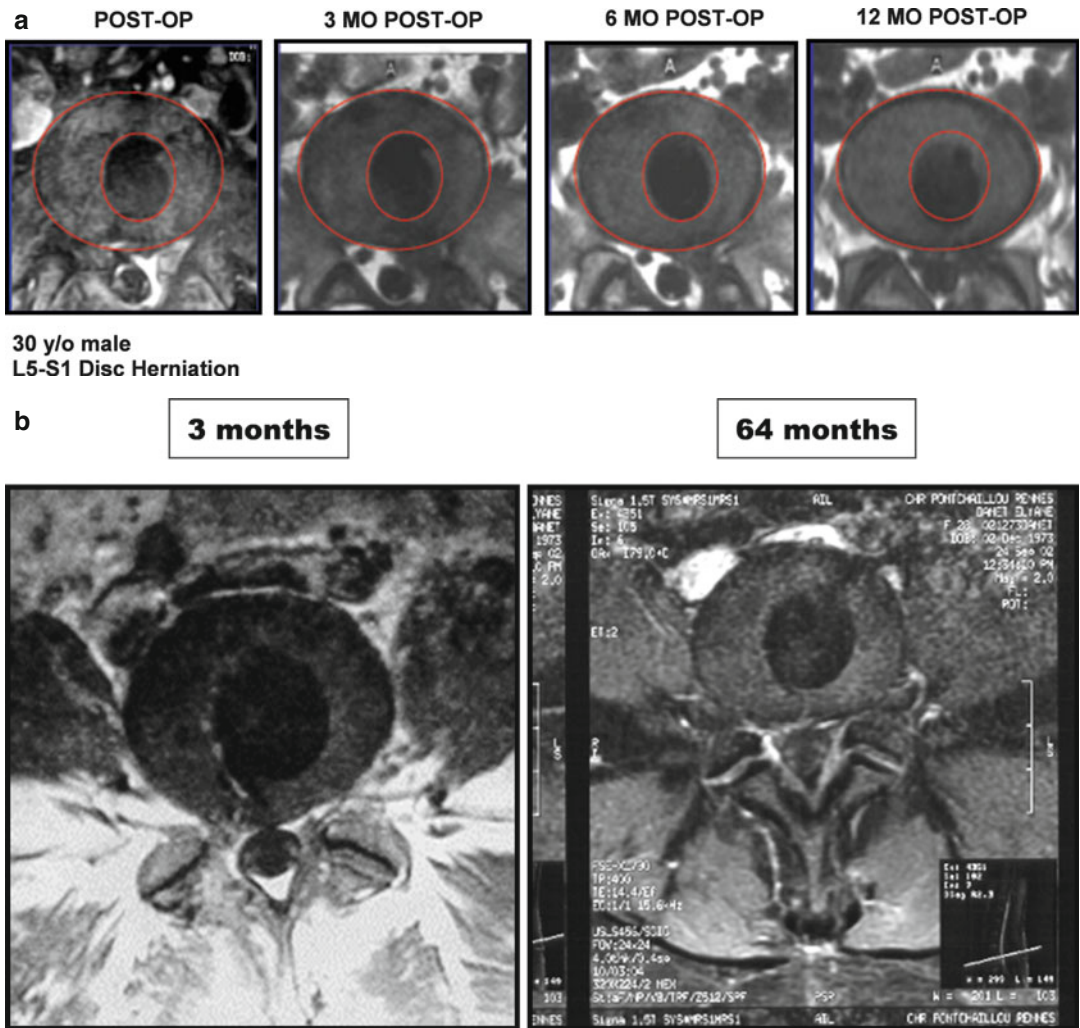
(a) Results at 12 months postoperative for patient no. 4; no change in the position, shape, coiling, translation, rotation, or cut plane of the implant. (b) MRI at 64 months postoperative for patient no. 1; no changes in the implant
